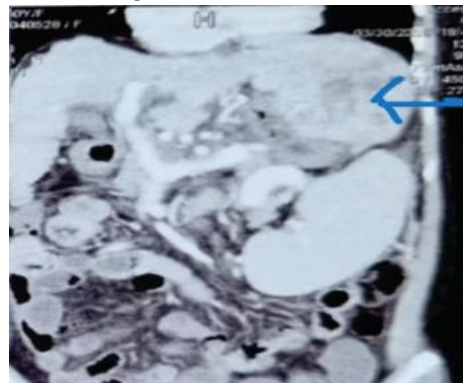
Triple Phase CT Scan Abdomen Showing Hepatocellular Carcinoma in Left Lobe Liver in SVR Achieved HCV Related Chronic Liver Disease Patient
